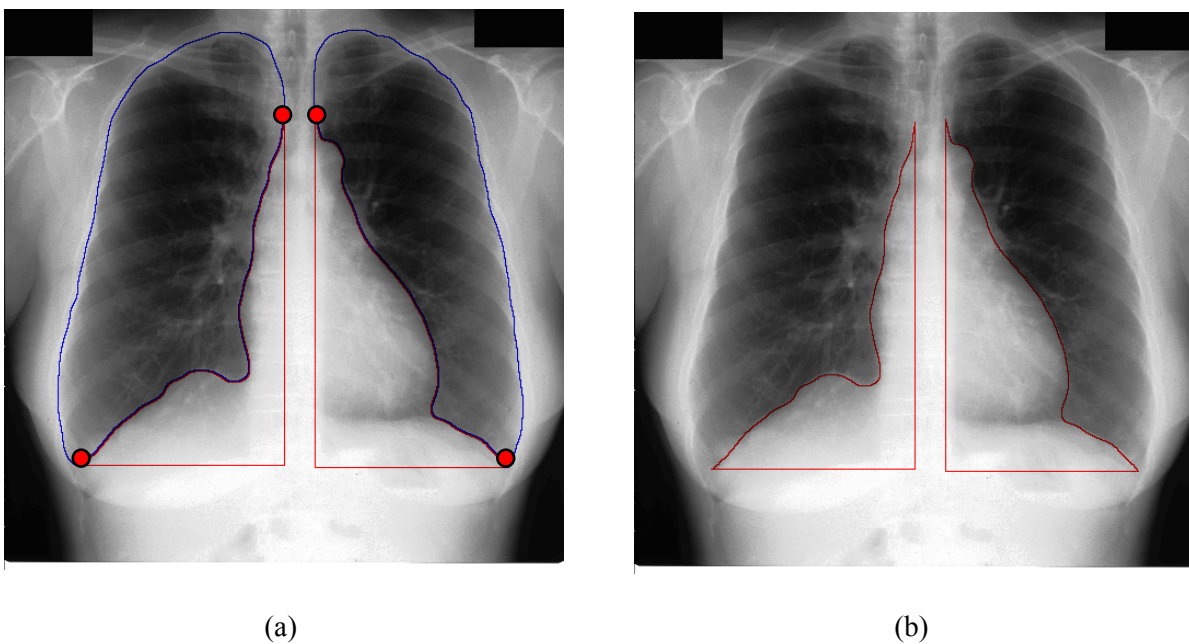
(a) chest radiographs (case JPCLN113) with the four key points highlighted; (b) chest radiographs with only the hidden lung region outlined.
